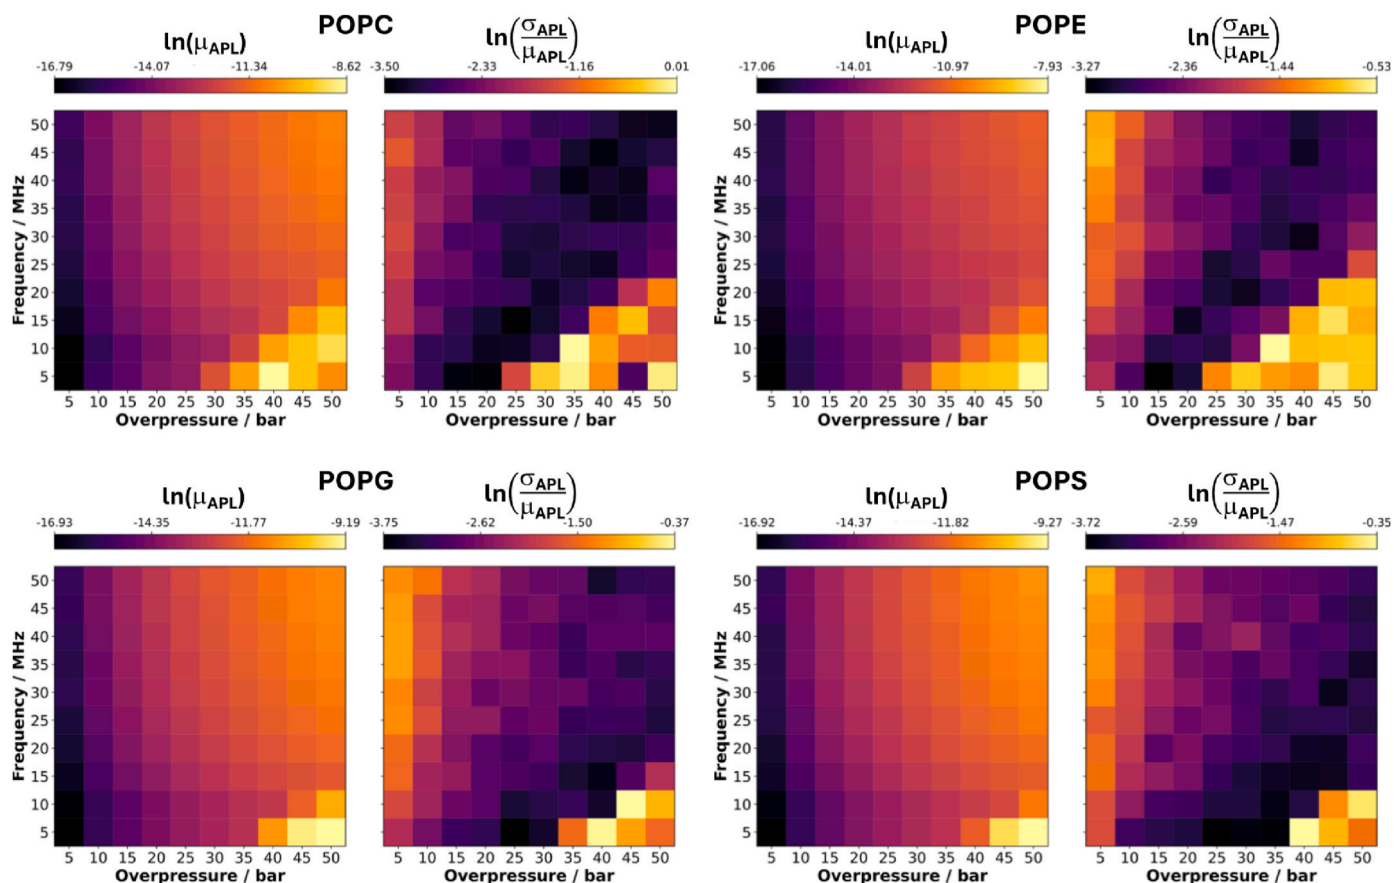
Area per lipid (APL) response for the studied systems under varying ultrasound conditions. Two heatmaps are plotted for each lipid bilayer: Logarithm of mean APL, $\ln(\mu_{APL})$, showing average membrane expansion or compression (left); and Logarithm of relative APL fluctuations, $\ln(\frac{\sigma_{APL}}{\mu_{APL}})$, indicating the magnitude of APL variations relative to its average value (right). Color scale: Blue indicates lower values, red higher values. This logarithmic representation enhances visibility of subtle variations across different ultrasound parameter regimes. (For interpretation of the references to colour in this figure legend, the reader is referred to the Web version of this article.)
